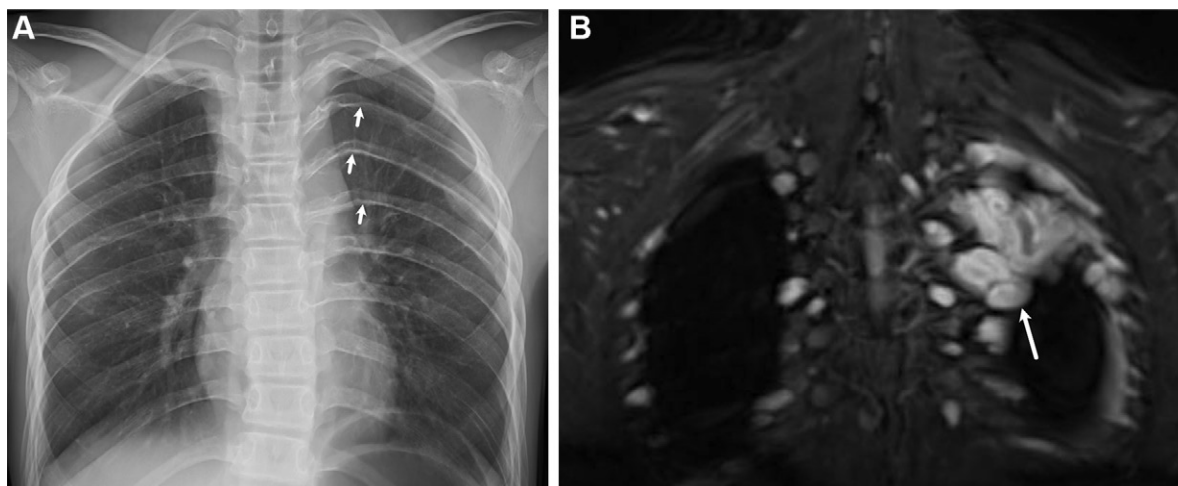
Rib notching and twisting in a 13-year-old girl with NF1. (A) Frontal chest radiograph shows rib notching and twisted rib deformity in bilateral upper ribs, which is much worse on the left (arrows). The left fourth rib shows severe rib notching with a ribbonlike appearance. (B) Coronal fat-suppressed T2-weighted MR image shows plexiform neurofibromas (arrow) extending along the intercostal nerves.
